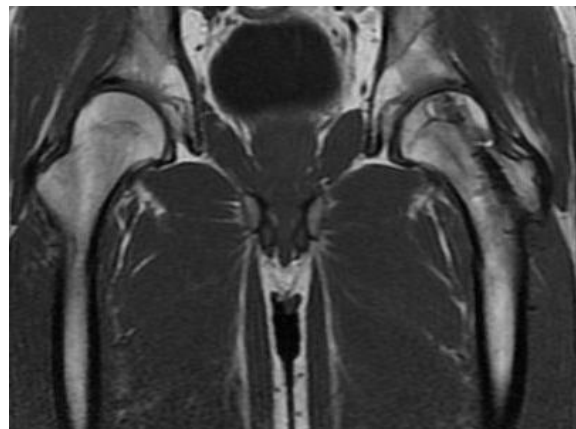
Postoperative sixth month MRI scan of the left hip. Note that the cyst is fully filled with graft, T1 weighted scan.
